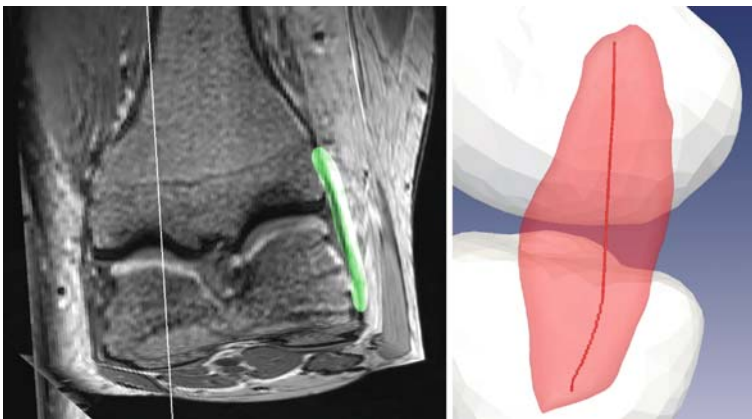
Segmented ligament mesh together with the original MRI data (*left*) and the extracted centerline connecting the attachment areas of femur and tibia (*right*)
